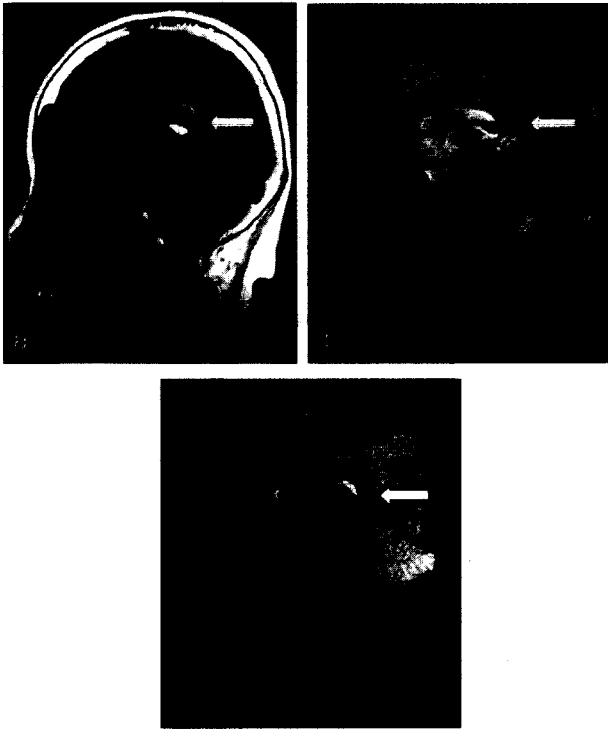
mid-sagittal MR imaging (a) T1 weighted MR imaging showed homogeneous high signal intensity lesion surrounding the splenium of corpus callosum and cistern of velum interpositum (5mm wide and 23mm in long). (b) Note the empty sella and corpus callosum is intact T2 weighted MR imaging showed iso signal intensity lesion. (c) T1-weighted fat suppression sequence revealed low signal intensity lesion confirming the fatty nature.
